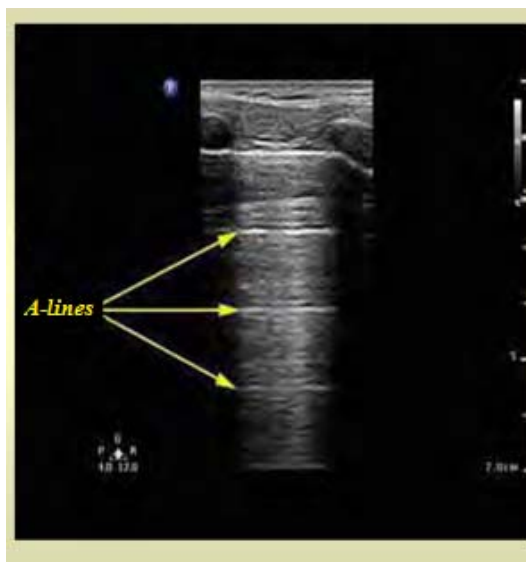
A-lines – bright horizontal lines, appearing under the pleura and standing parallel to it. They are artefacts created by the reflection of ultrasound from the pleura.
